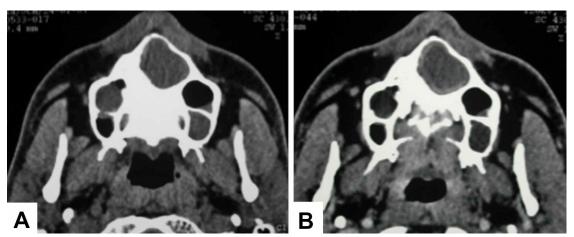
Axial CT before (Fig. 4A) and after (Fig. 4B) injection of iodinated contrast. Post-contrast peripheral enhancement indicates the cystic nature of the lesion.
